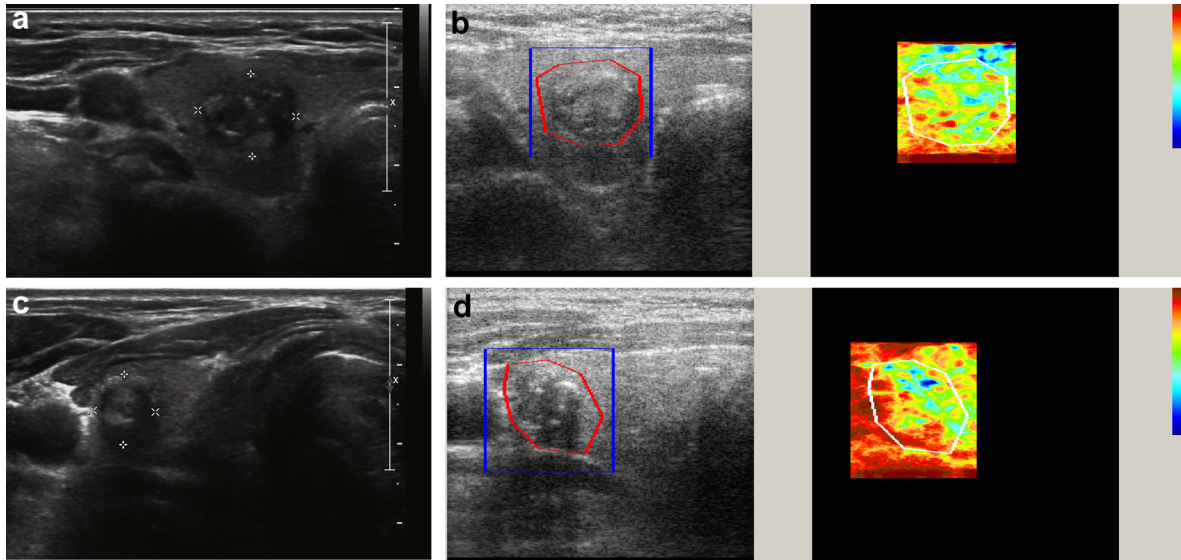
Representative cases of calcified nodules that were categorized as benign and malignant by elastography. (a, b) A 68-y-old woman presented with a 1.4-cm nodule on the right side of the thyroid. (a) B-Mode ultrasound revealed a hypo-echoic, spiculated, ovoid to round nodule with both micro- and macro-calcification. (b) Elastography revealed an elasticity contrast index (ECI) of 2.34, which indicated benignity (left: B-mode ultrasound, right: elastography). This nodule was confirmed as benign by fine-needle aspiration biopsy. (c, d) A 57-y-old man presented with a 1.3-cm nodule on the right side of the thyroid. (c) B-Mode ultrasound revealed an iso- to hypo-echoic, ill-defined, taller-than-wide nodule with both micro- and macro-calcification. (d) Elastography revealed an ECI of 3.93, which indicated malignancy (left: B-mode ultrasound, right: elastography). Fine-needle aspiration biopsy revealed a papillary thyroid carcinoma.
